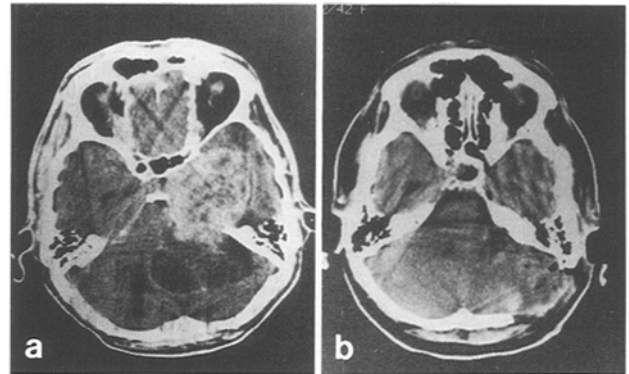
CT scan following contrast enhancement. (a) A dishomogeneous "hourglass" shaped mass occupying at the same time the left middle and posterior fossa is evident. (b) Postoperative scan demonstrates total tumour removal
